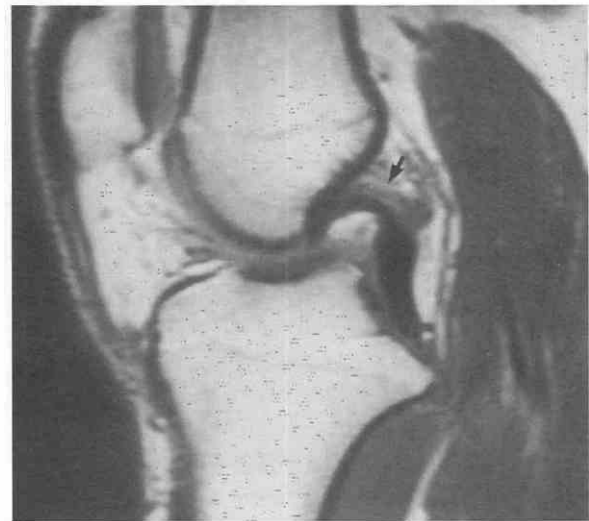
Buckling of the posterior cruciate ligament (PCL). Sagittal T1-weighted image shows buckling of the PCL (*arrow*). This is an indirect sign of the anterior cruciate ligament tear present in this patient. Also note anterior subluxation of the tibia.
